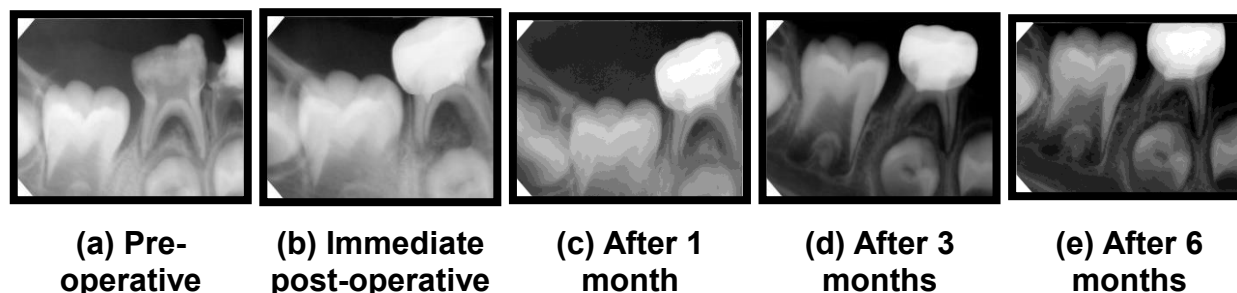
Radiographs show formacresol pulpotomy at different follow up periods (a, b, c, d and e)
